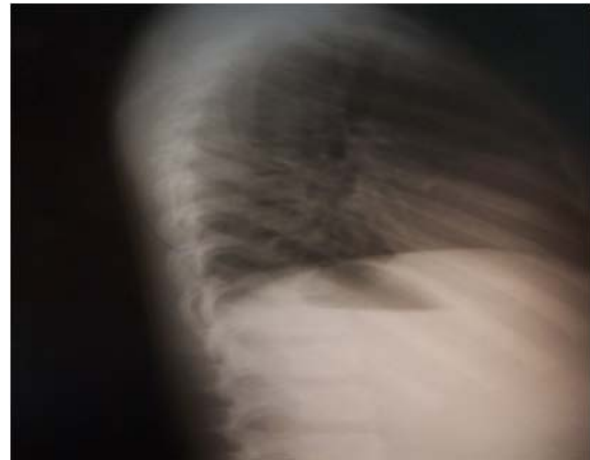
Lateral thoracic x-ray shows straight pin superimposing the vertebral column.
